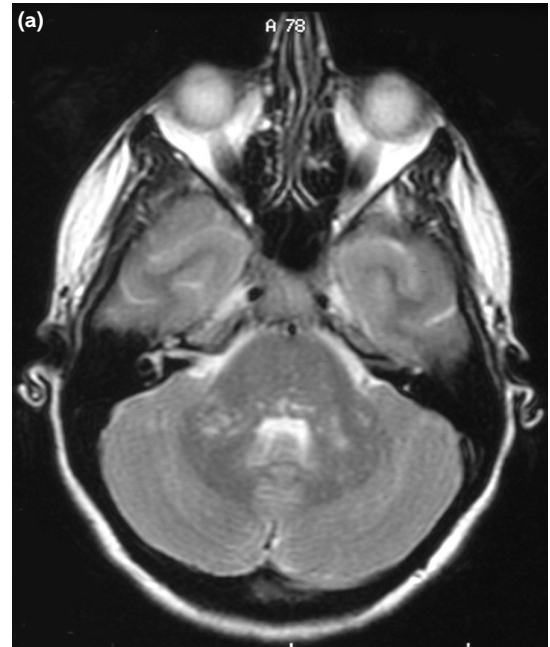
Progression of primary lesion on imaging: magnetic resonance image (MRI) at initial presentation (a) and MRI at 12 months of presentation (b).
